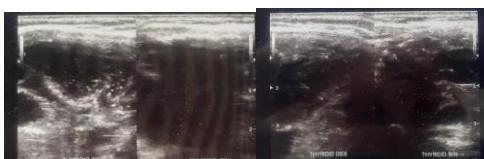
Ultrasound of thyroid showed right and left enlargement, wider – than – tall, visibly border of anechoic masses 9x8x6 cm, regular margin, TIRADS 1.
